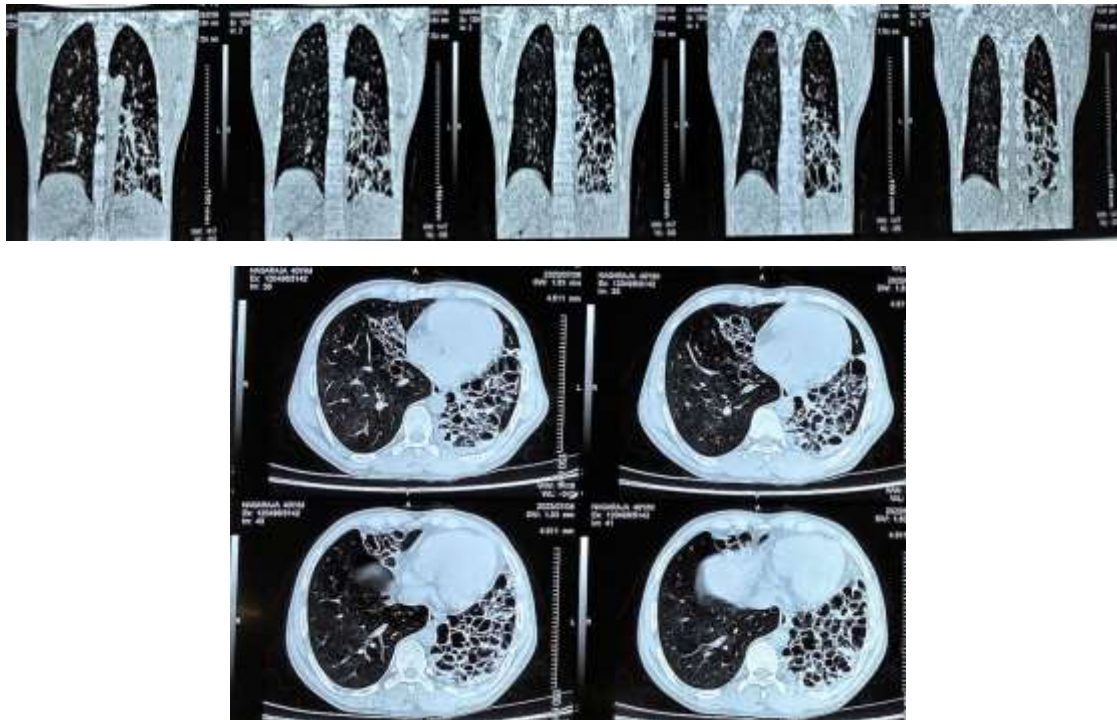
Chest HRCT showing cystic Bronchiectasis
